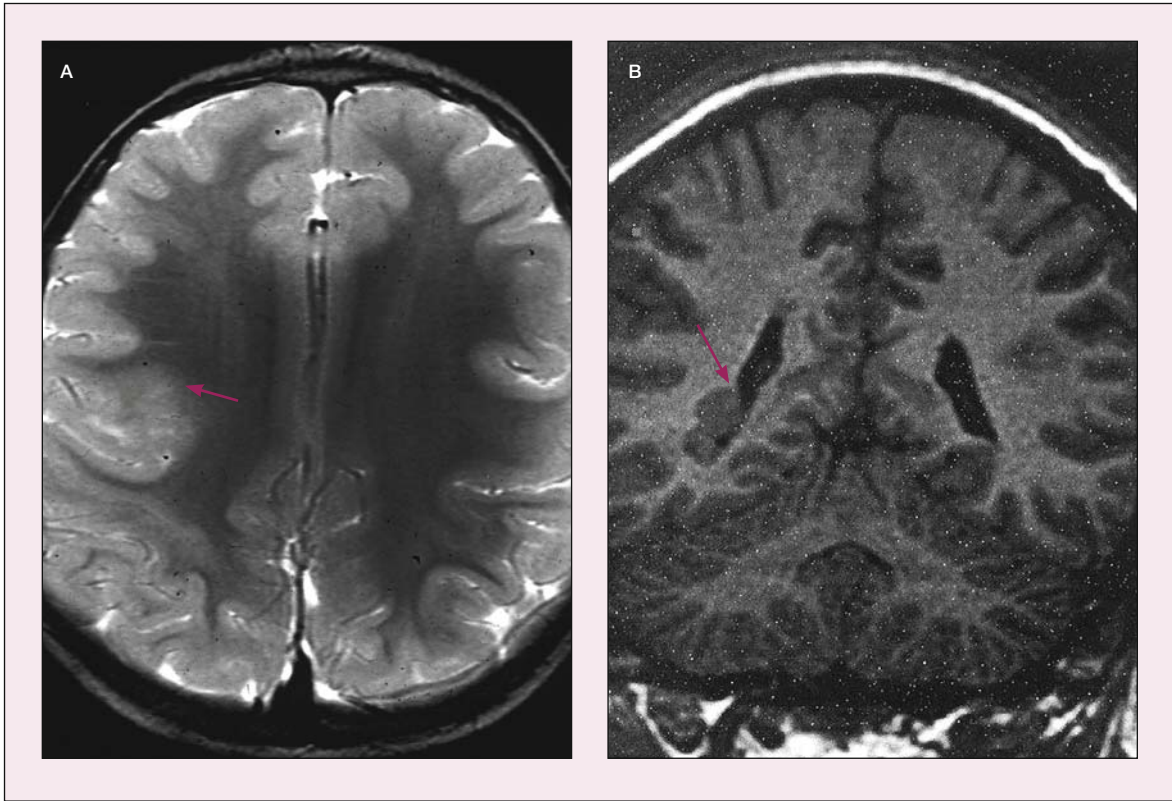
(A) Coronal T2-weighted MRI scan showing frontal focal cortical dysplasia (arrow). (B) Coronal T1-weighted MRI showing nodular subependymal heterotopia in the inferior lateral wall of the right lateral ventricle (arrow).
